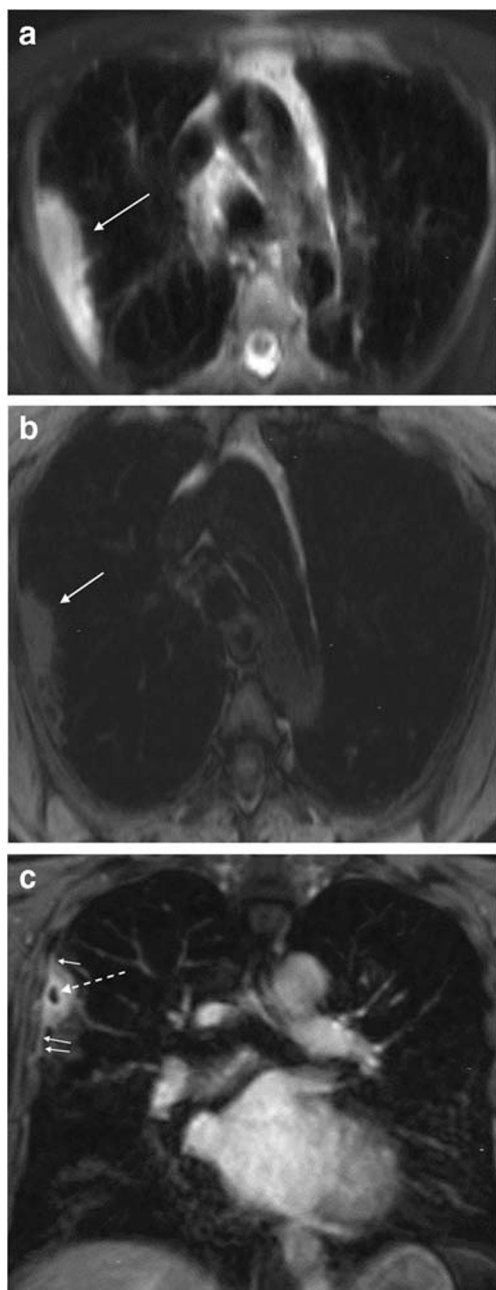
Cocci necrotic pneumonia. a Axial fat-saturated T2-weighted image and b pre-contrast axial T1-weighted gradient echo image demonstrates a T2 hyperintense and T1 hypointense consolidation. c Coronal post-contrast T1-weighted gradient echo image shows avid enhancement with internal cavitation related to necrosis (dashed arrow) and associated pleural inflammation (short white arrows) positive for cocci on biopsy
